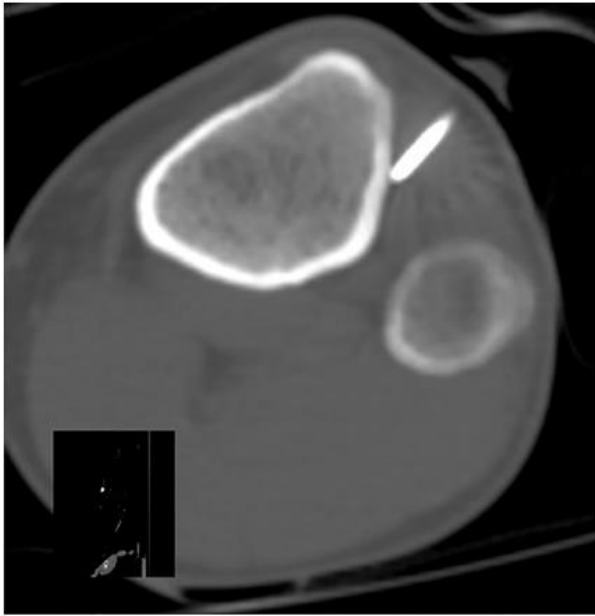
Axial bone-window CT images from short-volume tibial scans obtained in three different patients as part of posttrauma imaging.
